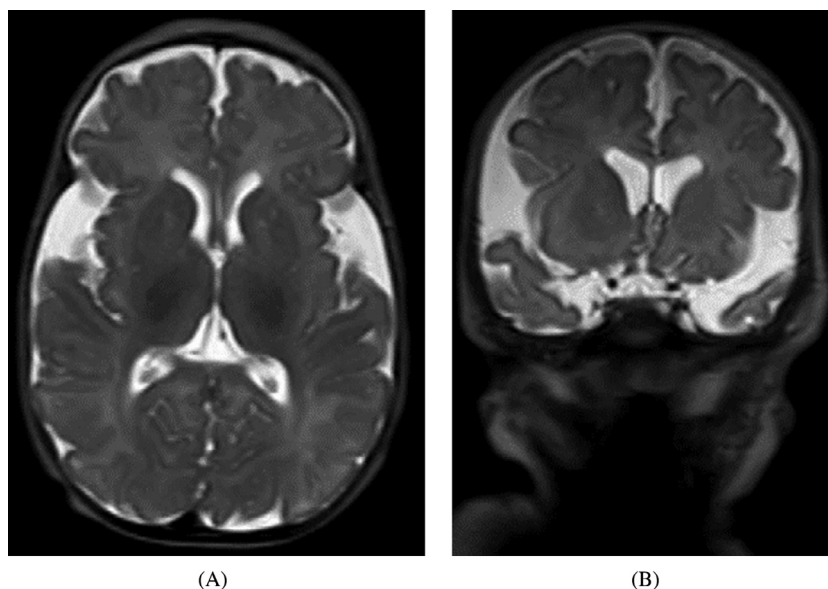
Glutaric aciduria type 1. (A) axial, and (B) coronal T2 images from a brain MRI examination of a 3 months old female infant who presented with macrocephaly and was later diagnosed with Glutaric aciduria type 1, demonstrate prominent subarachnoid spaces in the frontal and temporal regions with enlarged sylvian fissures.
